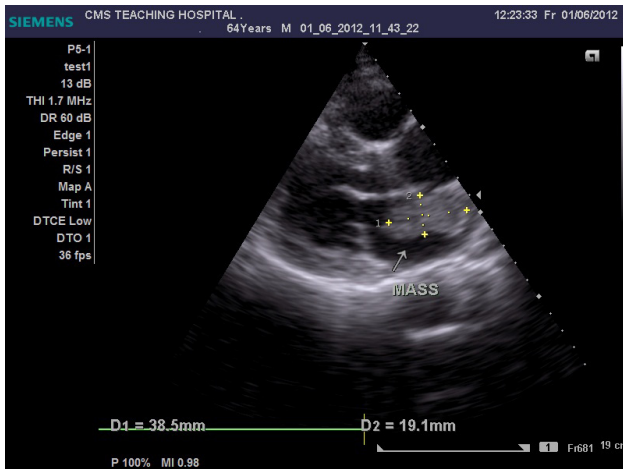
Transthoracic Echocardiography in Parasternal Long Axis View Showing a Heterogenous Mass in the Left Atrium Attached to the Interatrial Septum
